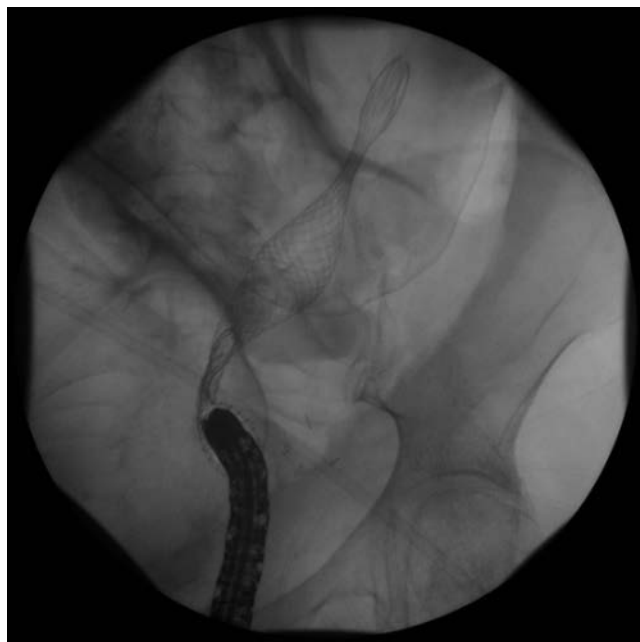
X-ray of stent in place. (Courtesy of Ochsner Clinic Foundation.)
